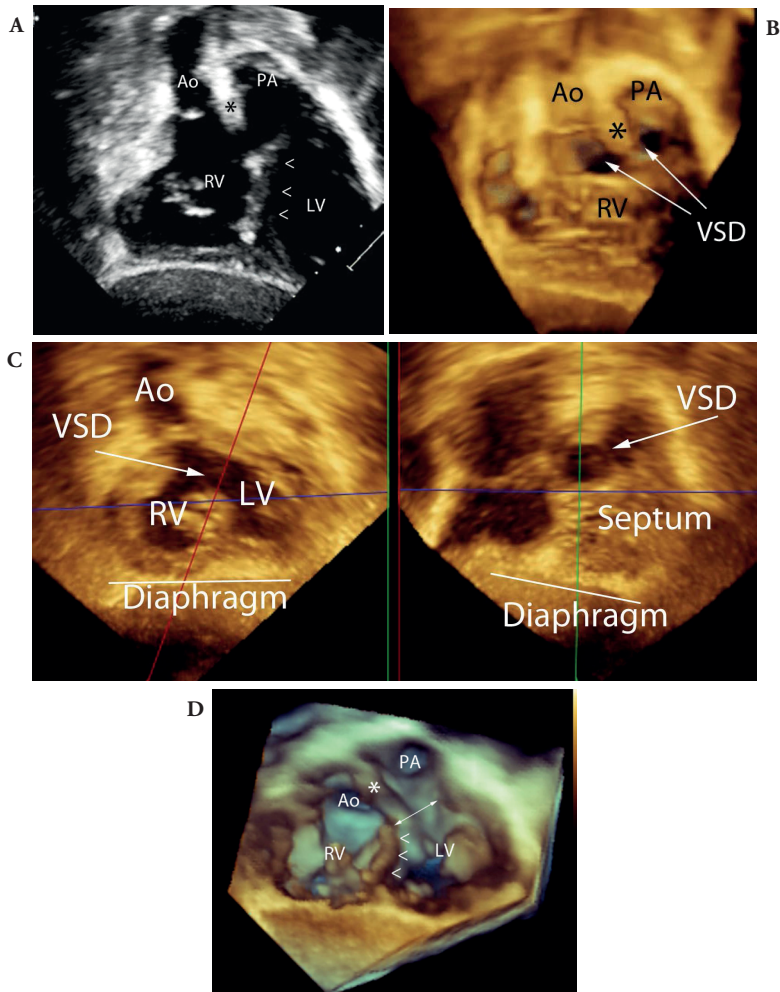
Transthoracic 3DE of double outlet right ventricle from a subcostal projection using a multi-beat acquisition. (A) Subcostal 2D echocardiographic view of double outlet right ventricle. The plane if the ventricular septum is shown by the arrows (<) and the outlet septum between the aorta and the pulmonary artery is shown by the asterisk (*). Note that the ventricular septal defect is not visualised as the outlet septum is entirely within the right ventricle and the plane of the ventricular septum would be posterior to the plane used in this image. (B) Subcostal 3D echocardiographic image of the same patient. The aorta (Ao) and the pulmonary artery (PA) are separated by the outlet septum (*). Due to the depth of field provided by the 3D image, the margins of the ventricular septal defect are clearly visualised. This is clinically important because the size and position of the ventricular septal defect may determine whether the left ventricle may be baffled to the aorta as part of the surgical repair. (C) MPR images showing the relationship of the ventricular septal defect to the aorta. The red plane is en face to the ventricular septal defect which is profiled in the right pane. This permits accurate measurement of the size of the ventricular septal. (D) 3D rendered image from the ventricular apex. The left ventricle and right ventricle are shown in short axis. The ventricular septum is shown by the arrowhead (<) and the ventricular septal defect is shown by the double-headed arrow. The depth of field of this projection shows the location of the ventricular septal defect, the outlet septum (*), and the relative position of the great arteries.
